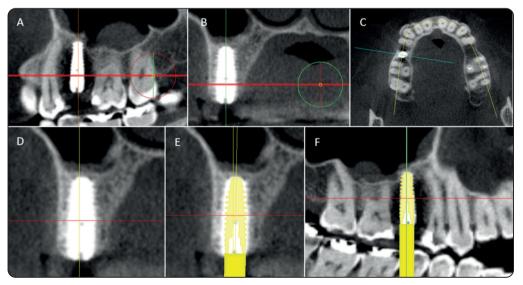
0M CBCT, (A & B) Orientation of axial images parallel to the software vertical line in the sagittal and coronal, respectively.
